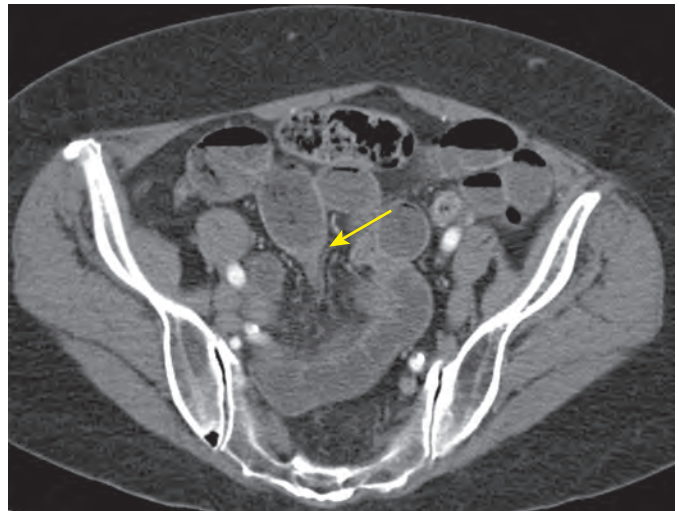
Narrowing at site of transition zone. Axial CT scan through the lower abdomen demonstrates dilated small intestine. There is an abrupt transition (arrow) between the collapsed and obstructed small bowel. The small bowel feces sign is present proximal to the obstruction.
